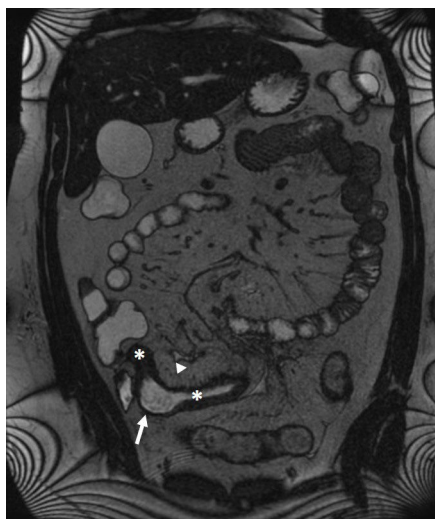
SSFP T2-weighted MRE image in the coronal plane. Two consecutive ileal strictures (*asterisks*) with sacculation between the strictures (*arrow*) in a patient with CD. The coronal plane also allows assessment of non-intestinal structures and the mesentery. Note the hyperaemia of the vasa recta afferent to the diseased segment (*arrowhead*).
